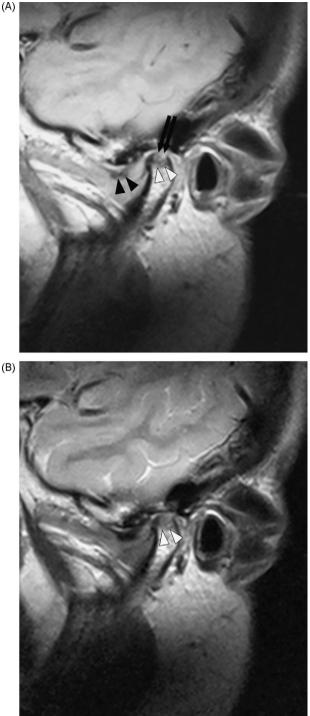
MR images. Parasagittal proton density-weighted closed-mouth image (A) shows decreased signal from bone marrow of condyle (white arrowheads). There was also irregularity of upper surface (erosion) of condyle (black arrows) and temporal joint component suggestive of osteoarthritis. Disk was anteriorly displaced and deformed (black arrowheads). Parasagittal T2weighted closed-mouth image (B) shows decreased signal from bone marrow of condyle suggestive of osteonecrosis (white arrowheads).
